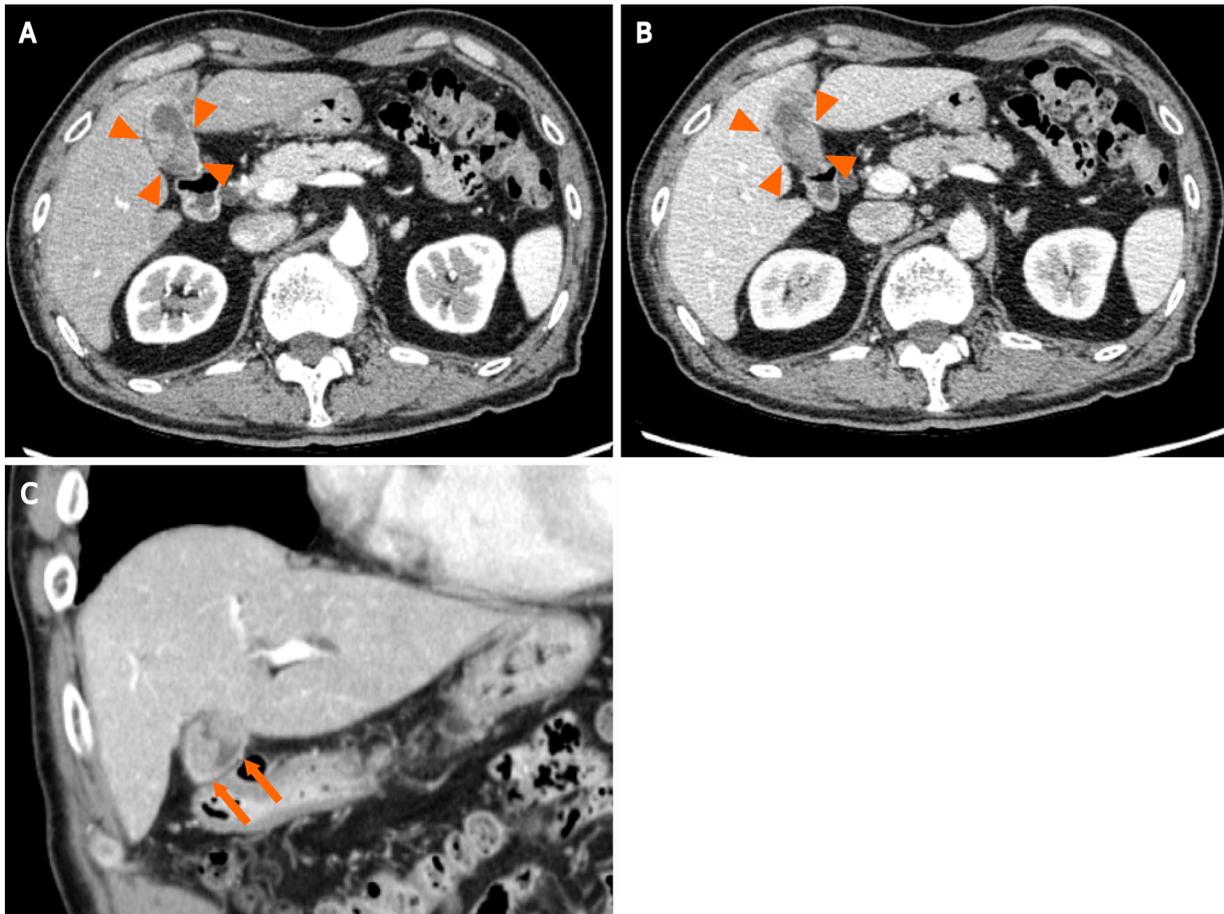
A contrast-enhanced abdominal computed tomography scan shows two irregular and highly contrast-enhanced masses (arrowheads and arrow) at the neck and body of the gallbladder as well as periportal lymph node enlargement, which is consistent with gallbladder cancer lymph node metastasis. A: Axial section image in the early phase showing neck of the gallbladder; B: Axial section image in the delayed phase showing neck of the gallbladder in the delayed phase; C: Coronal sectional image showing body of the gallbladder.
